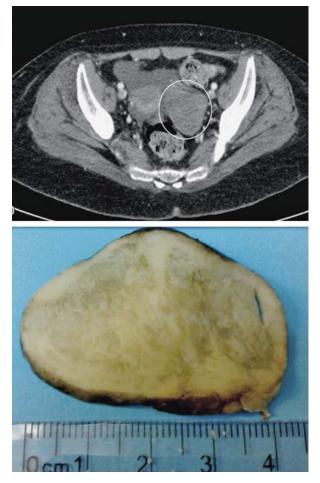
Computed tomography scan of the pelvis showing a wellcircumscribed left adnexal mass (top). The cut section is homogenous white-yellow in color and firm in consistency (bottom).
